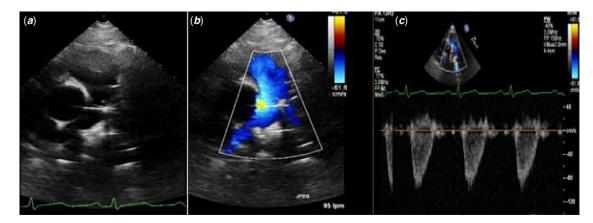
Echocardiogram. A) PSAX: We can see the device in the pulmonary trunk near the left branch origin, B) With colour Doppler with laminar flow. C) Pulsed Doppler with a peak velocity of 1 m/s. No obstruction gradient.
